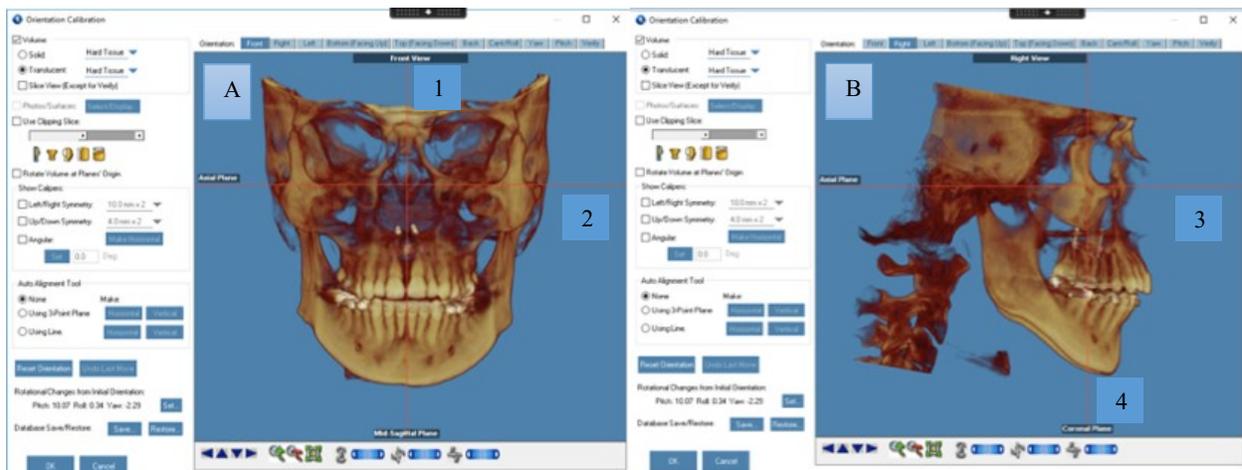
Head orientation of the CBCT scans. (A) Frontal view. (B) Sagittal View. Images were oriented based on (1) Skeletal midline, (2) Lower border of the orbit, (3) Frankfort horizontal plane, and (4) Line passing through furcation of maxillary first molars^{86,89}
